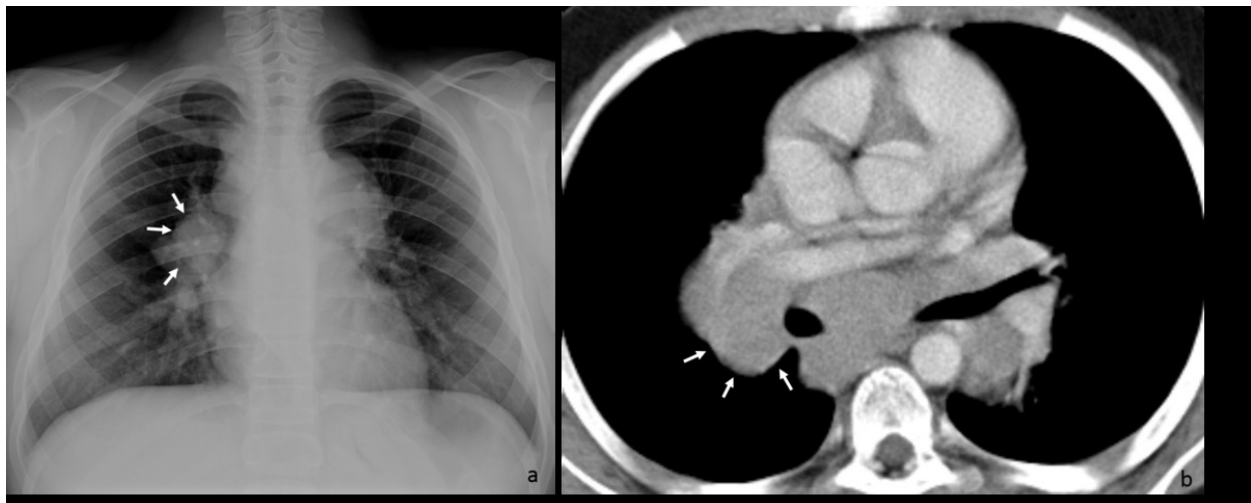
The chest radiograph (a) of a young patient demonstrates enlarged and lobulated hila, with a convex hilar angle (white arrows). The CT of the same patient (b)
